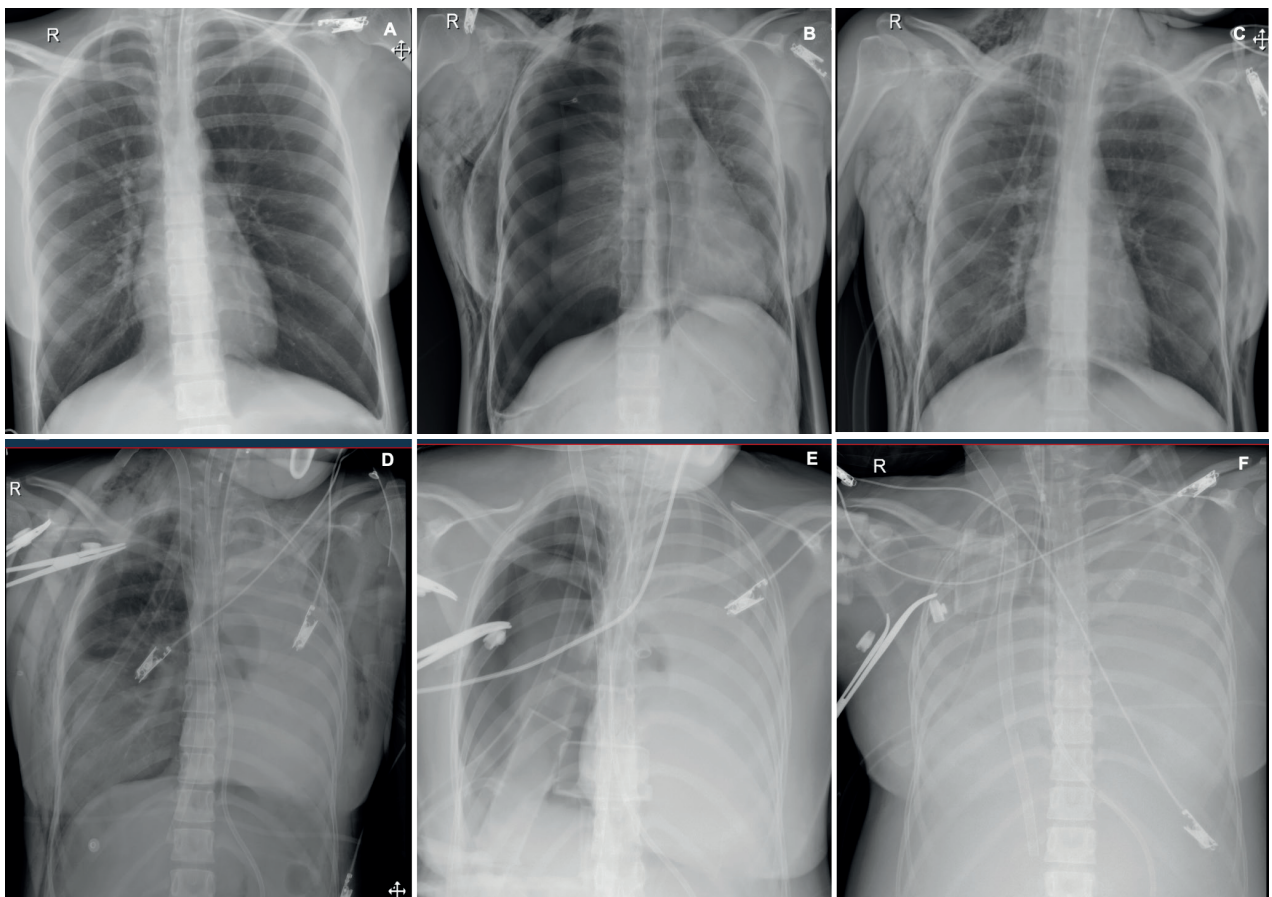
Sequential chest X-ray of case 1. A. Signs of pulmonary hyperinflation with diaphragmatic flattening. Orotracheal tube in proper position, there are no consolidations and pleural angles are free. B. Severe right pneumothorax, subcutaneous emphysema, displacement of mediastinal structures to the left. Presence of a nasogastric tube. C. Mild pulmonary expansion with large subcutaneous emphysema. The chest tube is directed towards the pulmonary apex, a superior vena cava catheter is placed. D. Complete opacity of the left hemithorax with ipsilateral displacement of mediastinal structures, suggestive of atelectasis and presence of a hernia in the right lung. There is subcutaneous emphysema on both pulmonary fields. E. Severe right pneumothorax with complete collapse of the lung, right chest tube, mediastinal displacement to the left. F. Complete opacity of both pulmonary fields due to massive pleural effusion, right chest tubes and displacement of the trachea to the right. R: right side.
